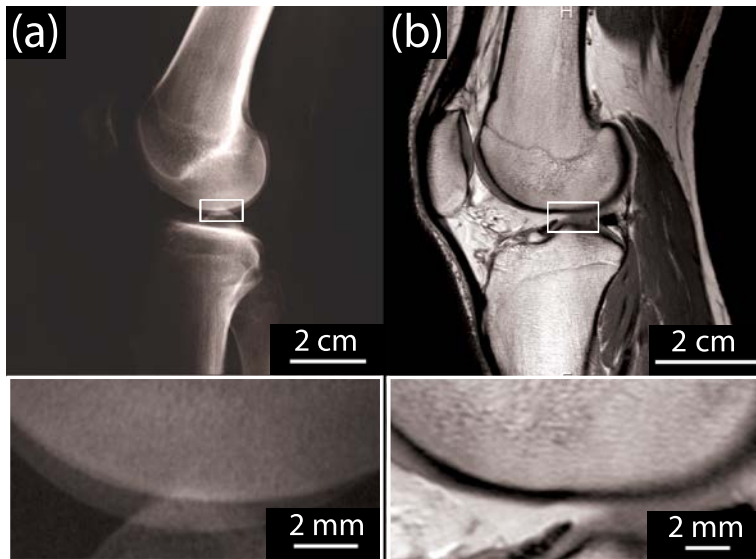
Picture of a left knee taken by (a) X-ray radiography and by (b) MRI. The insets exhibit the articular cartilage surface imaged with the two same technics.
